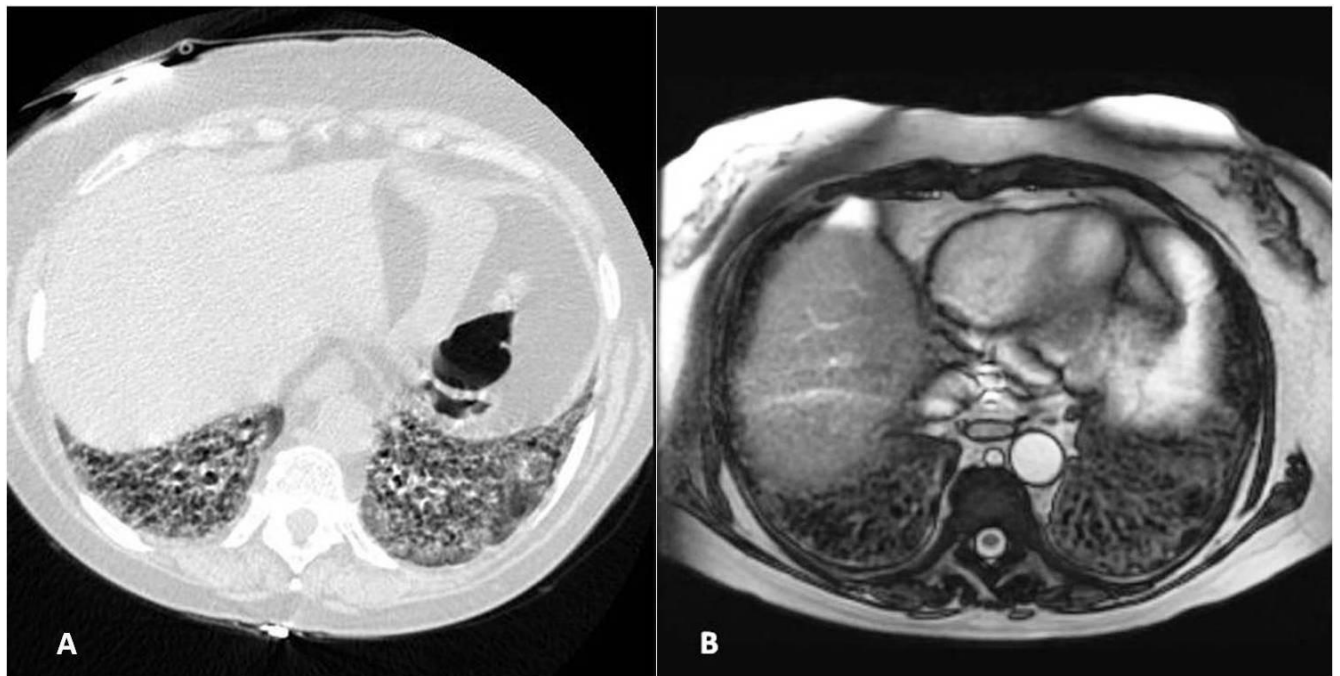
CT (A) and bSSFP MRI images (B) show the presence of cystic reticular pattern of fibrosis in the lung bases
